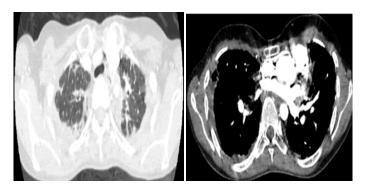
Thorax CT manifestations of the PPFE revealing pleural thickening, subpleural parenchymal fibrosis, platyhorax, and suprasternal notch deepening [36].
